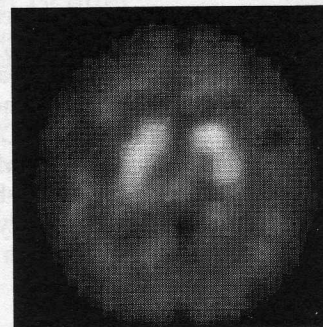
Neuroreceptor SPECT Image
